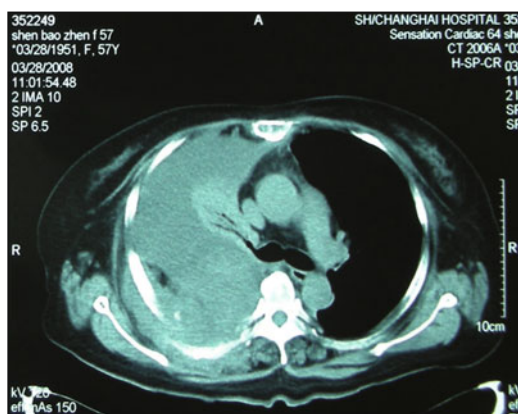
Images when the patient felt chest distress and breathlessness. CT scan showed surrounding soft tissue mass of manubrium sterni and the right fifth and sixth posterior segment of ribs, right large volume pleural effusion with floating mass.
